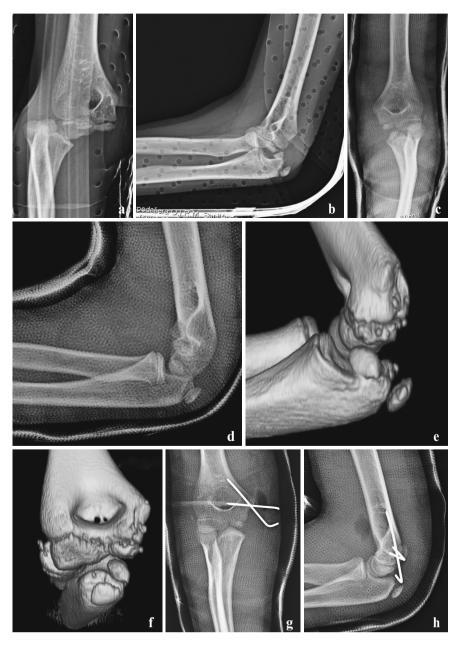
Medial epicondyle fracture with elbow dislocation (a-b); after reduction, entrapment of the epicondyle is visible (c-d), better confirmed with CT images (e-f); post-reduction X-ray with Kirschner wire fixation (g-h)
